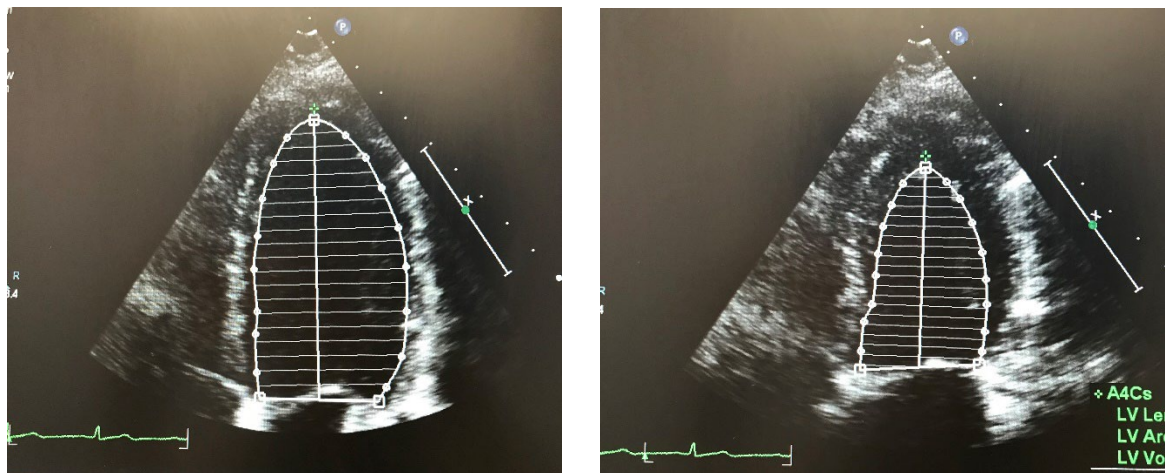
Apical four chamber left ventricular volume in diastole (left) and systole (right)
